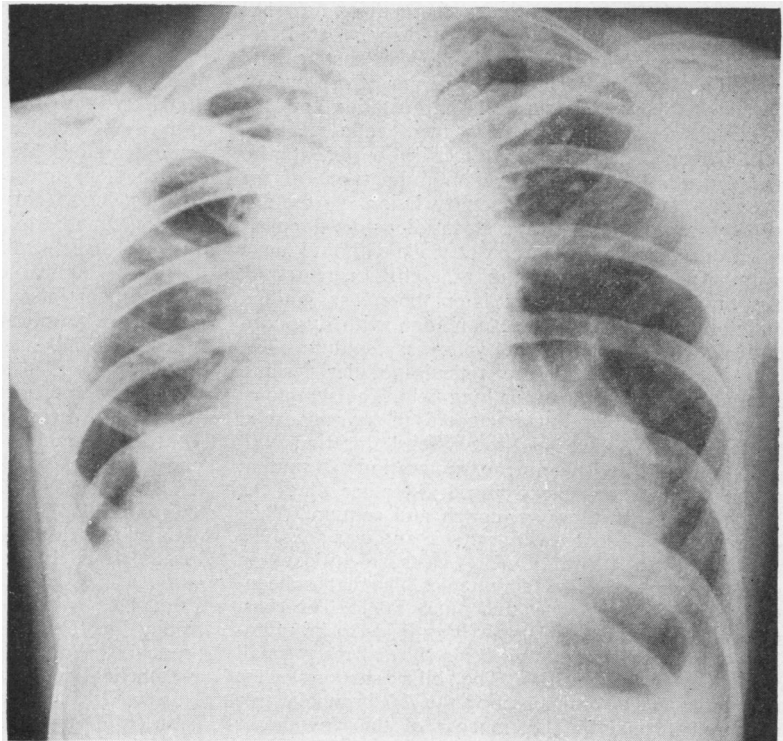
Case 3. Radiograph shows advanced pulmonary fibrosis, most marked in the hilar portions of the lungs, with peripheral pulmonary emphysema which obscures the pulmonary infiltrates. Pre-operatively the hilar masses were incorrectly assumed to be largely due to hilar lymphadenopathy.*
